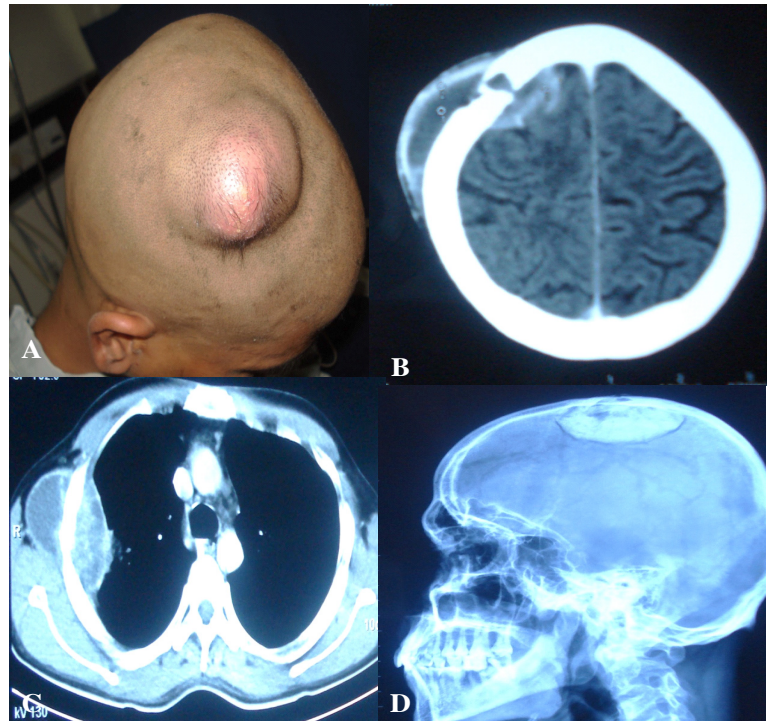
A) Scalp lump, B) CT scan of brain showing scalp lump with bony erosion with epidural collection, C) CT chest showing chest wall cold abscess, D) Post-op X-ray skull showing cranioplasty with bone cement
